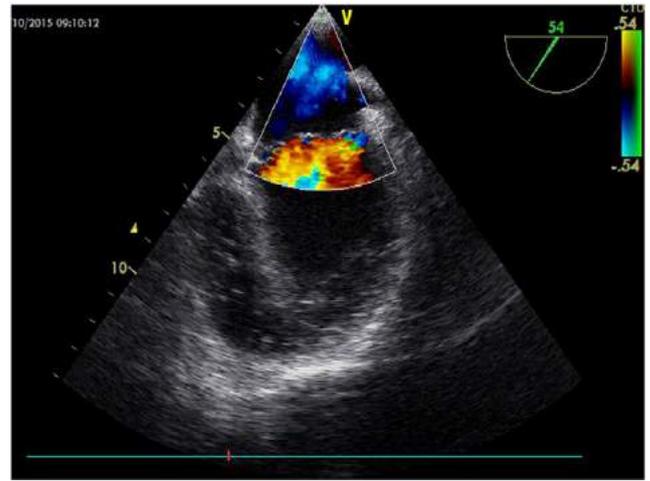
Colour doppler examination is not showing turbulent flow in the left atrium.
